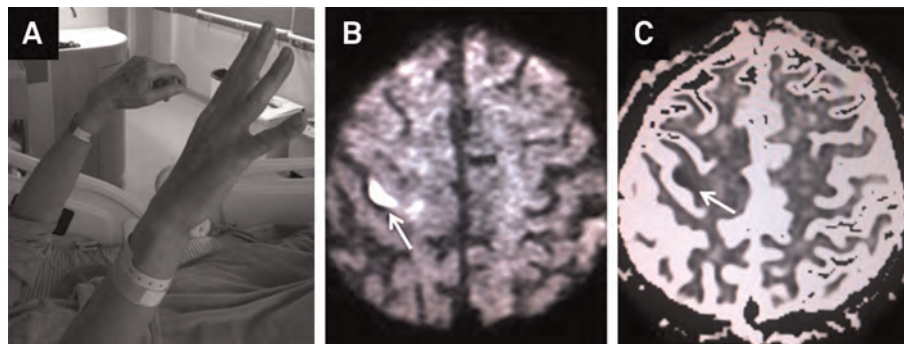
Patient with dropped hand and inability to extend left wrist, thumb and fingers (A). Diffusion-weighted brain MRI showing a small area of restricted diffusion in the left frontal cortex (B). ADC map-weighted brain MRI disclosing an hypointense signal in left frontal cortex supporting the diagnosis of acute ischemic stroke (C).
